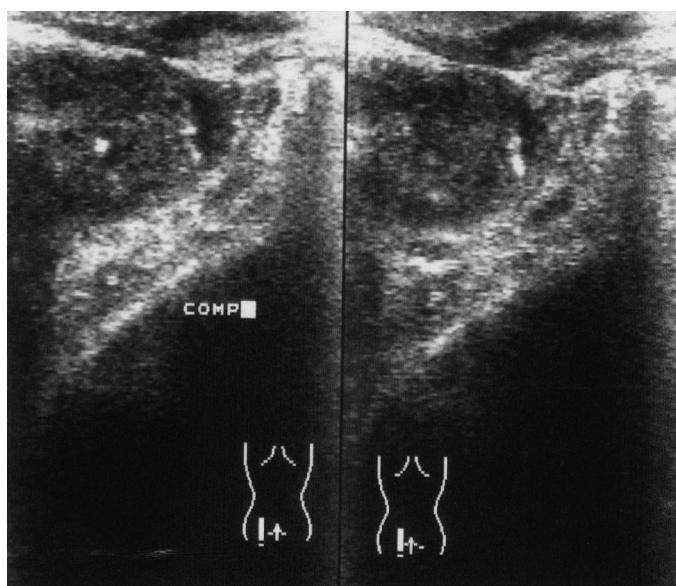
Transrectal ultrasound with linear array probe shows small hypoechoic subcapsular prostate lesion in periphery of prostate (left). When pressure was applied with probe, lesion shape changed from spherical to oval. This deformability was considered indicative of nonmalignant lesion.
